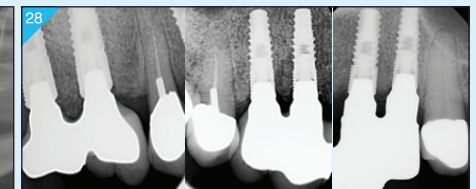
Radiograph after delivery of implant restoration.
